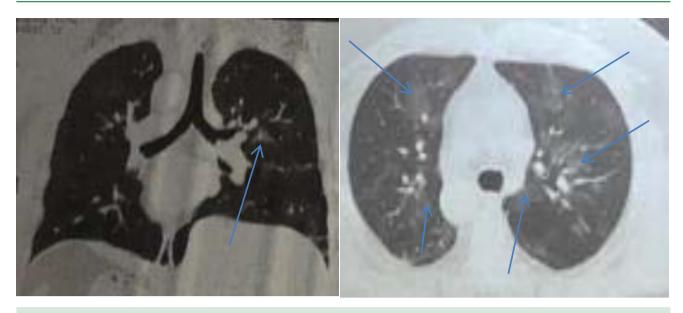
CT of patient N., 38 years old
